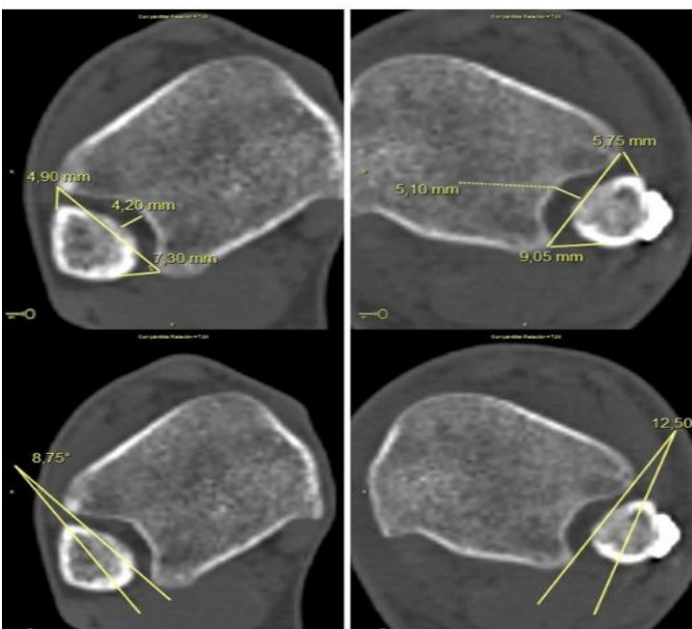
Post-operative CT scan to assess the post-operative reduction of the left ankle for comparison using the Mukhopadhyay method (16).
